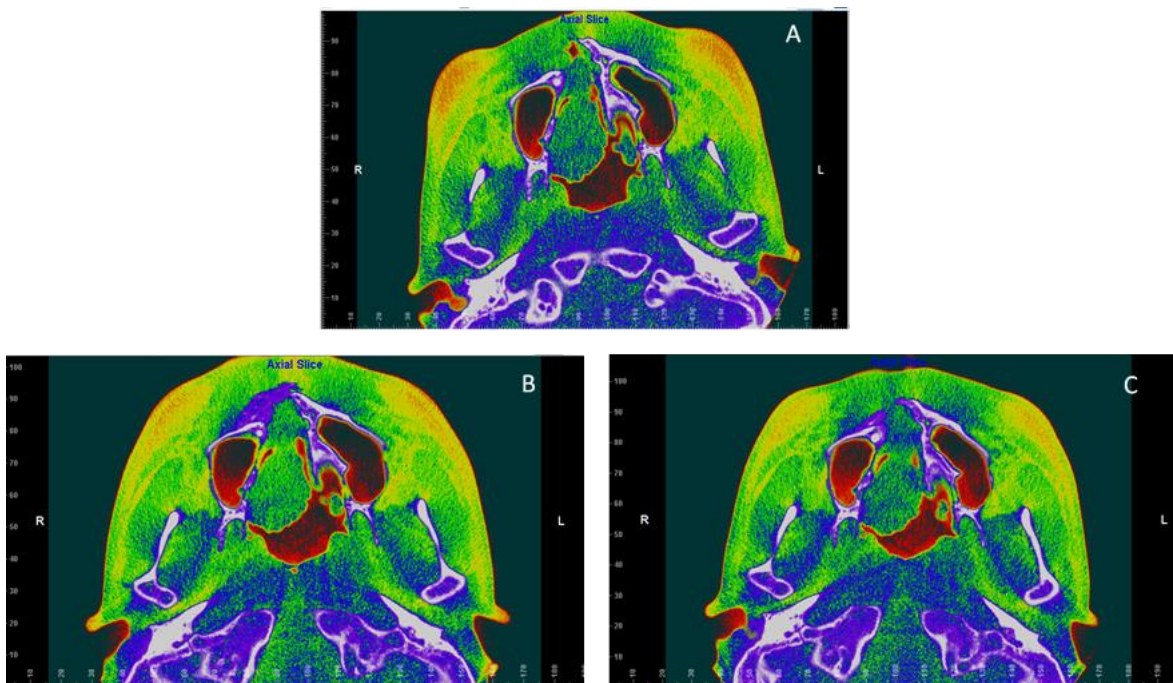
A) CBCT HU's variation before bone graft. B) After the surgery, two CBCTs were taken with 15 days and C) 60 days to analyze the volume and the density of the bone graft.
